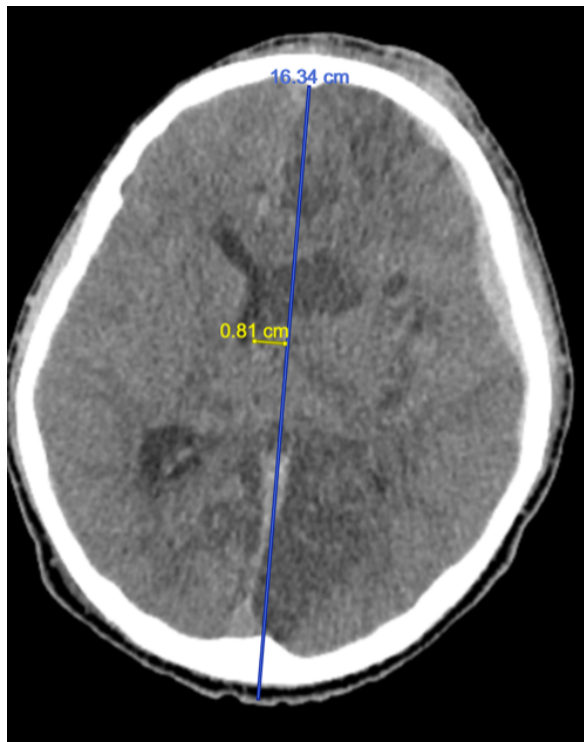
Non-contrast CT demonstrating a left acute subdural hematoma with approximately 8 mm MLS, with effacement of the basal cisterns and early ischaemic changes. The degree of MLS is consistent with Stage 2 subfalcine herniation within the proposed framework.
